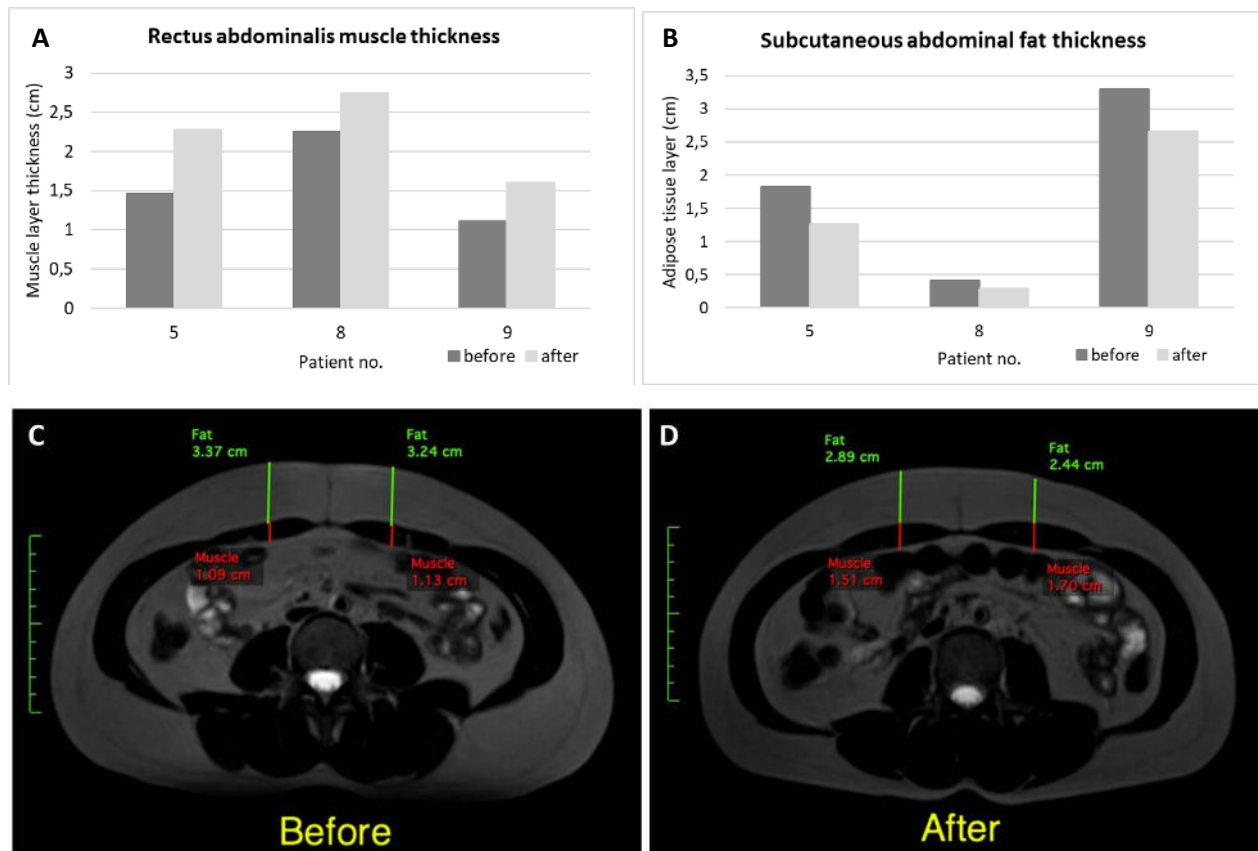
A - Measured change in rectus abdominis muscle thickness before and 10 weeks after the FMS treatment, taken from MRI transverse abdominal sections from 3 patients; B Measured change in abdominal subcutaneous fat muscle thickness before and 10 weeks after the FMS treatment, taken from MRI transverse abdominal sections from 3 patients; C and D – example of an MRI image of patient No. 9 taken before (A) and 10 weeks after (D) FMS treatment
